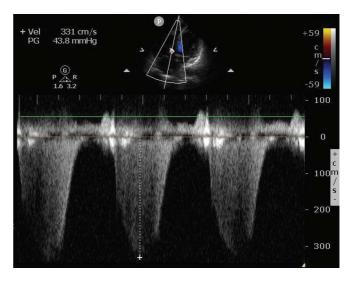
Continuous wave Doppler assessment of the tricuspid regurgitant jet in pulmonary hypertension. Using the modified Bernoulli equation, the $V_{\rm max}$ of 3.3 m/s leads to a pressure gradient (PG) of 44 mmHg. Assuming the inferior vena cava is >2.1 cm in diameter with <50% respirophasic change, the right atrial pressure is 15 mmHg. Therefore the right ventricular pressure (and pulmonary artery systolic pressure) is 59 mmHg. Pressures exceeding 60 mmHg suggest chronic pulmonary hypertension.
